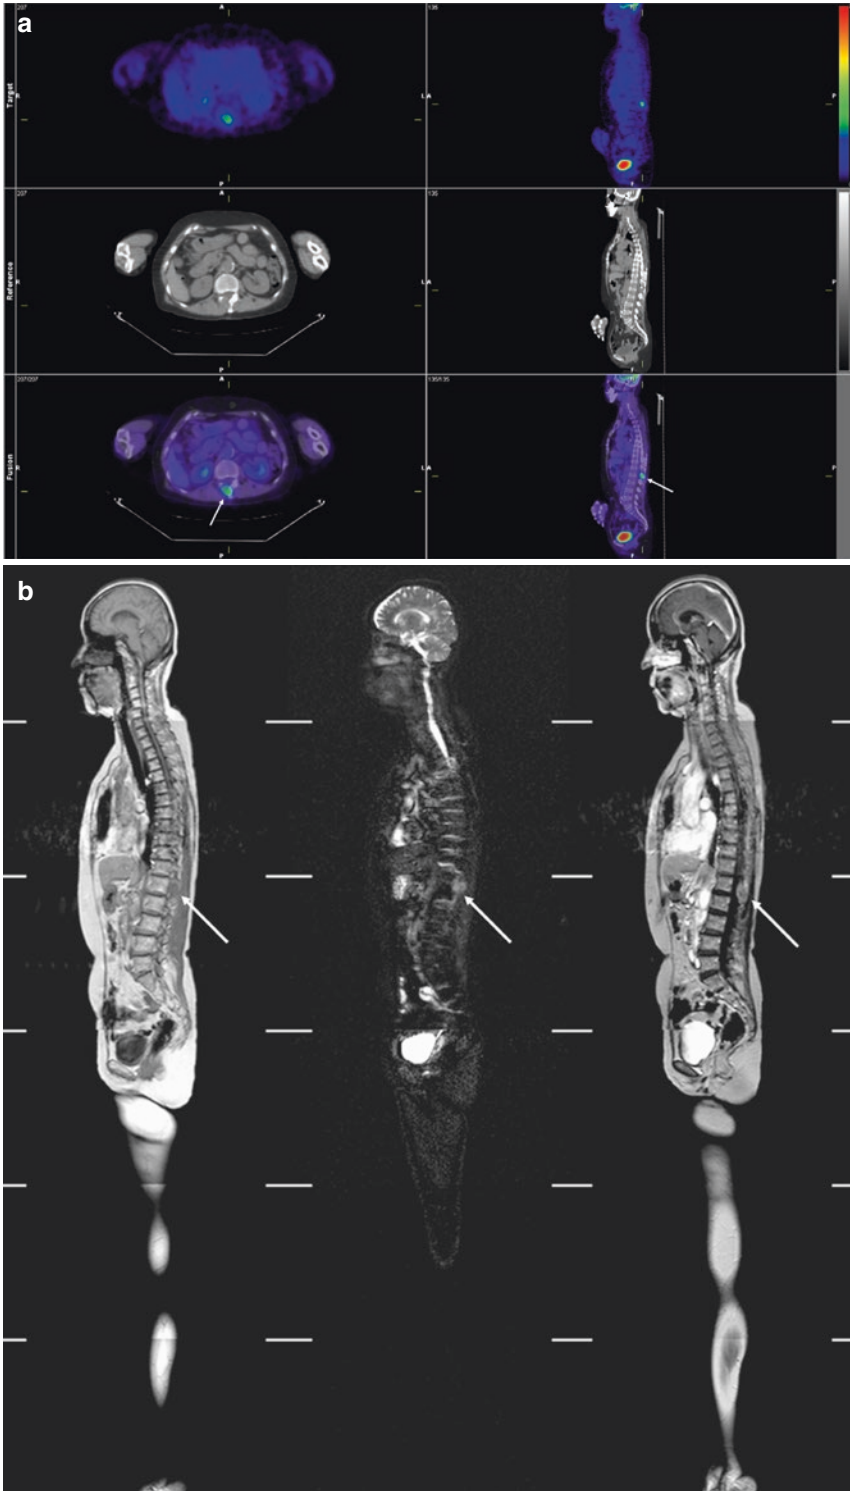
A 68-year-old female with adenocarcinoma and lumbar vertebra (L1) metastasis. Integrated FDG-PET/CT (a) shows high uptake of FDG at the vertebral arch (arrow), suggesting bone metastasis, which was true-positive. On
